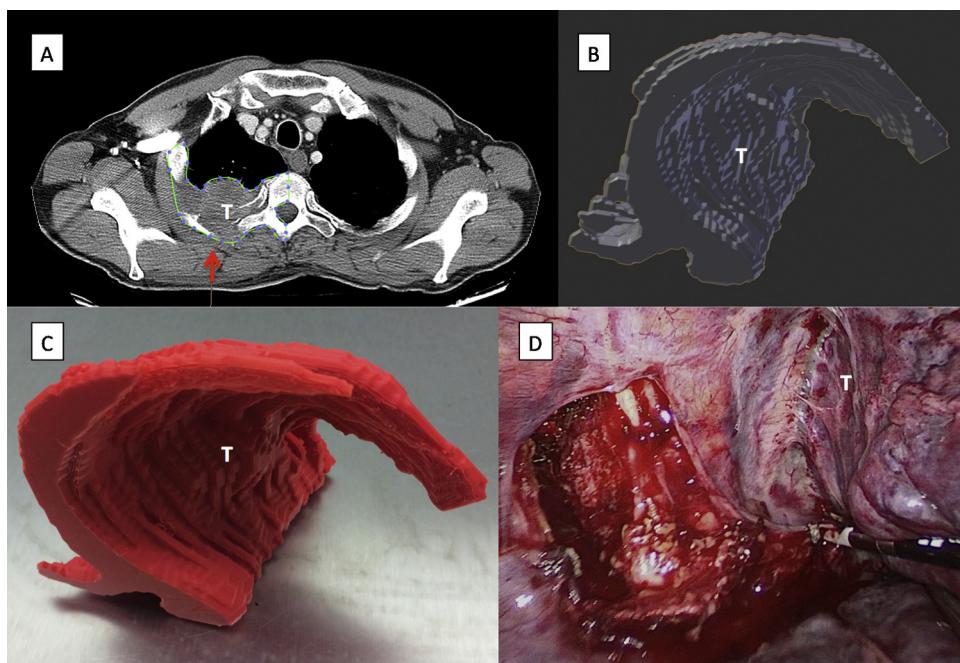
Right upper lobe pancoast tumor. (A) Computed tomography of the tumor (T) with region of interest (green line) around the tumor, ipsilateral side of spine and the chest wall (red arrow). (B) 3D rendering of extracted topology showing tumor (T), spine and chest wall. (C) 3D printed plastic model of the tumor (T), spine and chest wall. (D) Thoracoscopic image of the resection of the chest wall and laminectomy with tumor (T) invading the third rib.
